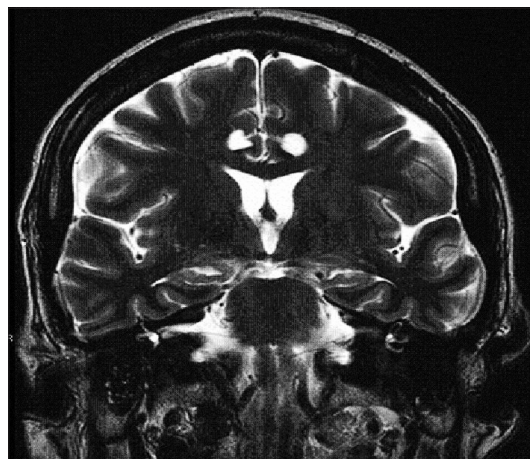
Coronal postoperative T2-weighted MRI image demonstrating modern bilateral anterior cingulotomy
